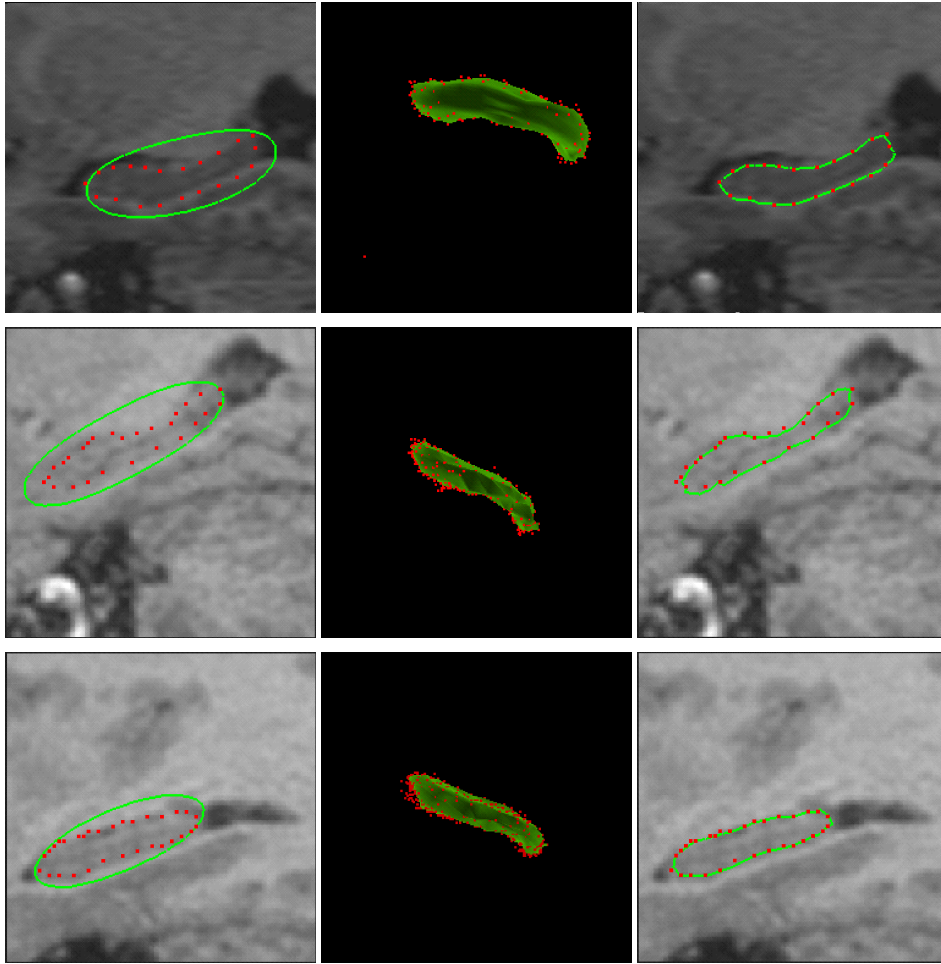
Model Fitting using the deformable pedal surface. First row: (MRI scan of a healthy volunteer superposed with boundary points placed by a neuro-scientist on a slice (dots) and a slice (white curve) of the initialized deformable pedal surface model (left), fitted model (center) followed by a slice of the fitted model superposed on the corresponding MR slice (right). Second row: MRI scan of a patient with left medial temporal lobe focus. Third row: MRI scan of a patient with right medial temporal lobe. Third column shows that fits are visually accurate.
